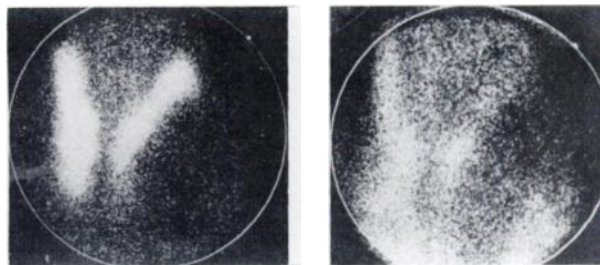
Case 2. Technetium-99m-pertechnetate thyroid scintigraph (left) shows cold mass in left lobe. Indium-113m perfusion image (right) shows no perfusion of corresponding cold lesion (colloid nodule cyst).
